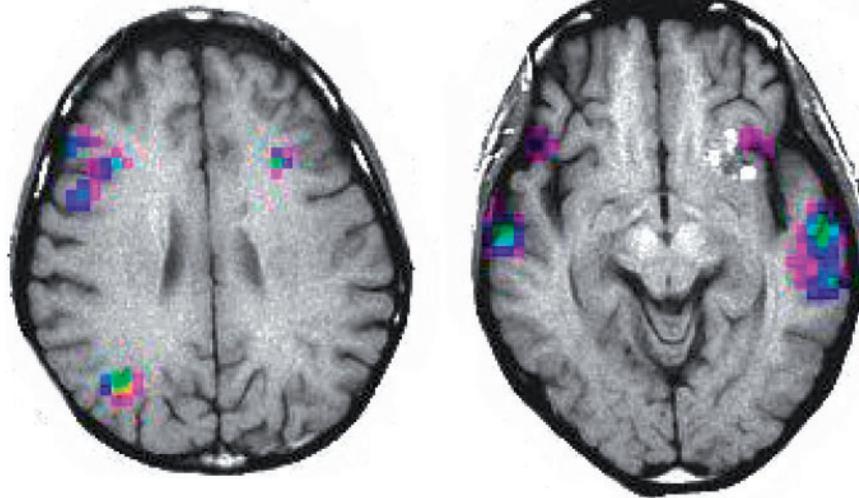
Functional MRI of language. Example of a subject with inter-hemispheric dissociated Broca's–Wernicke's area lateralization (one area in the left hemisphere and the other one in the right). MRI displayed with radiological convention: Left hemisphere is located in the right. Left image: activation obtained with a paradigm of semantic fluency. Right image: activation in primary and secondary auditory areas from a passive listening task. Notice frontal areas associated with expressive language located in the right hemisphere while posterior receptive areas are dominant on the left hemisphere. Activation is colour coded for signal intensity from magenta (weak) to blue to green to yellow (strong). (Images courtesy of Miami Children's Hospital, Department of Radiology).
